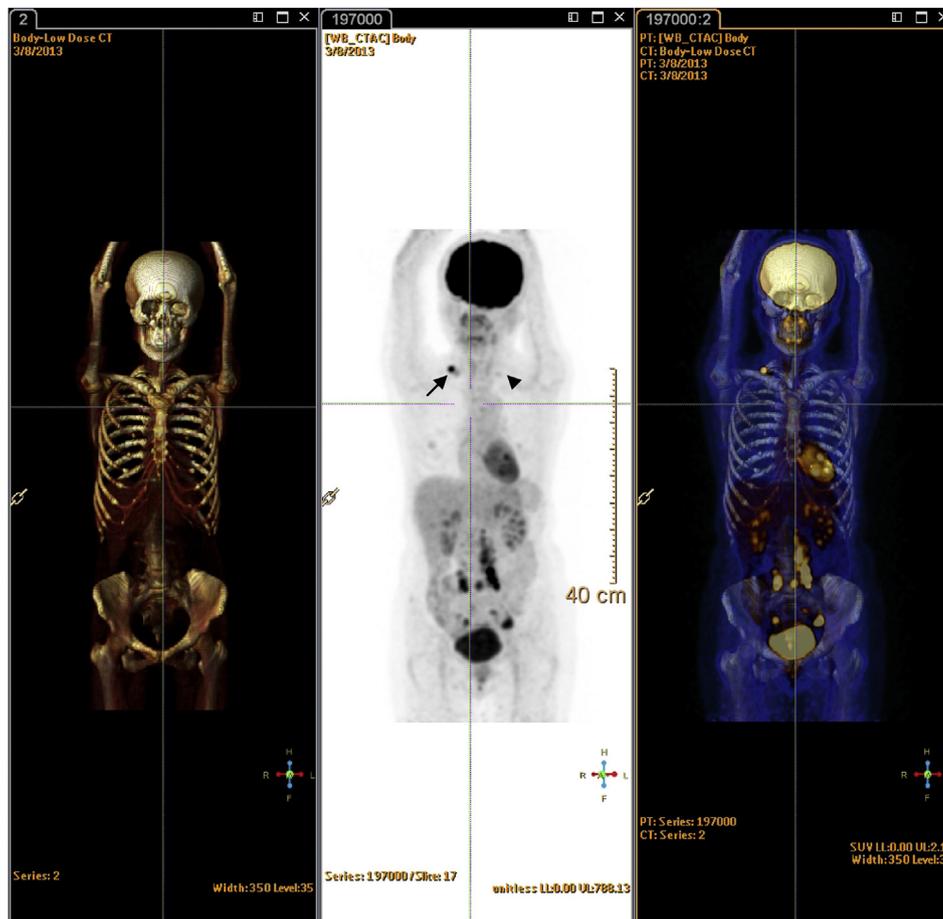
Whole body PET/CT scan. Anterior projection image of PET/CT scan with F-18 fludeoxyglucose (FDG) showed increased FDG activity at the para-aortic, pericaval, and subaortic of abdomen, the bilateral iliac, and the right supraclavicular regions (arrow), indicating metastatic lymphadenopathy. In addition, a metastatic lymph node at the left supraclavicular region was also suspected (arrow head). CT = computed tomography; PET = positron emission tomography.
